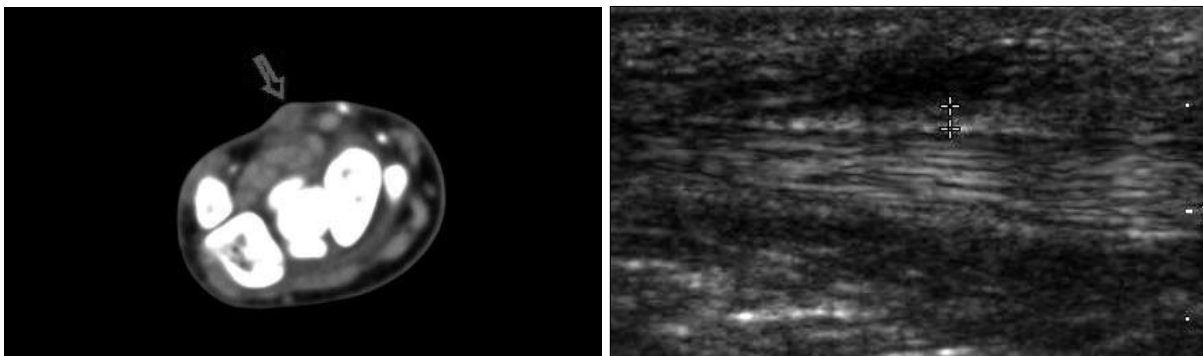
(Left) CT shows a 1 × 1 cm sized solid mass on the palmaris longus tendon. (Right) Sonography image shows 1.0 × 0.8 cm sized hypoechoic lesion on the palmaris longus tendon.
